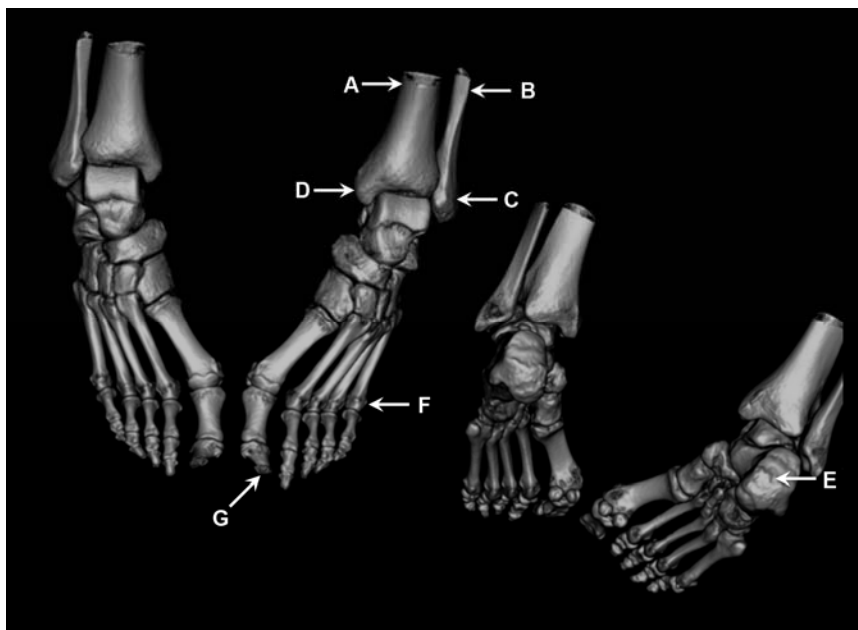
Listing of the 7 anatomical landmarks (A–E, see text) used to quantify misalignment between CT and SPECT images.
